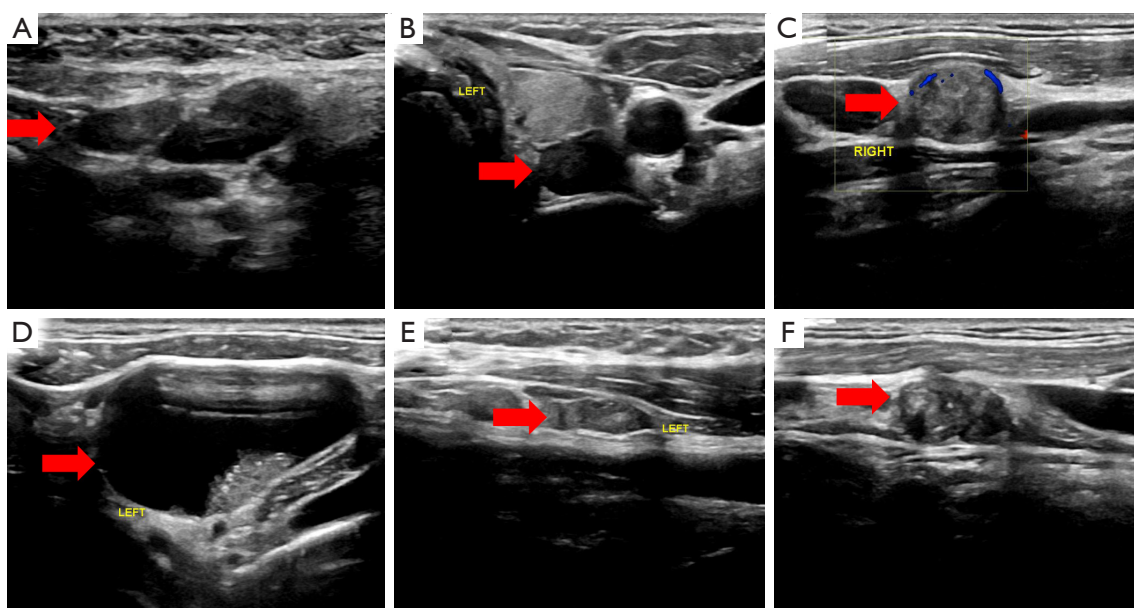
Ultrasonography is used to evaluate lateral cervical lymph nodes. The arrow refers to cervical lymph nodes. (A) Normal lymph nodes; (B) irregular shape; (C) $L/S \leq 1.5$; (D) cystic necrosis; (E) lymph hilar structure disappeared; (F) calcification. L/S, long diameter/short diameter.
